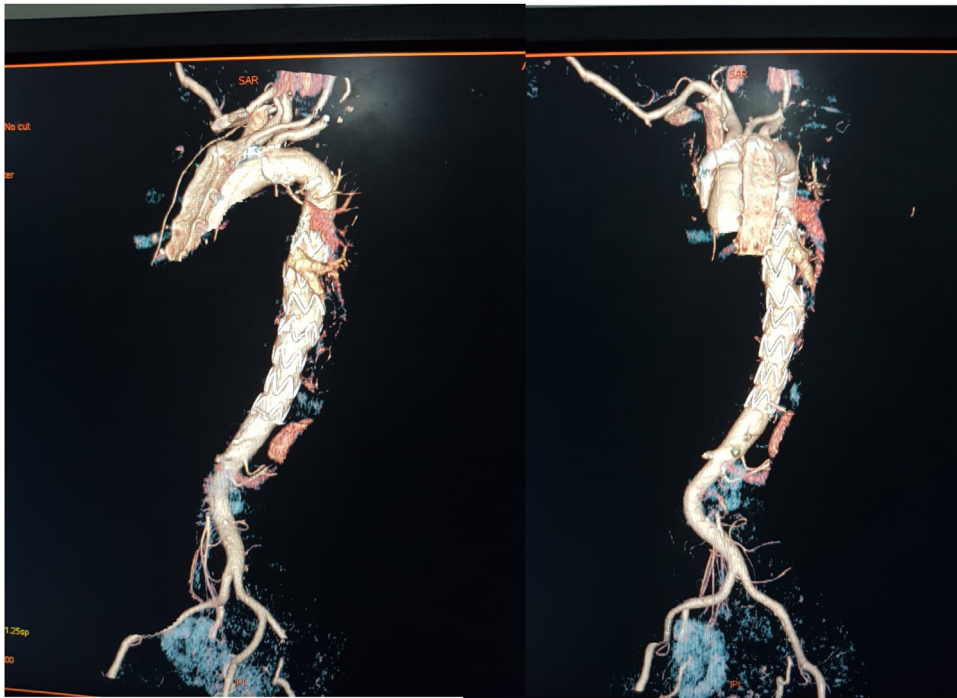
CT scan showing the total exclusion of the aneurysm and the absence of endoleaks.
